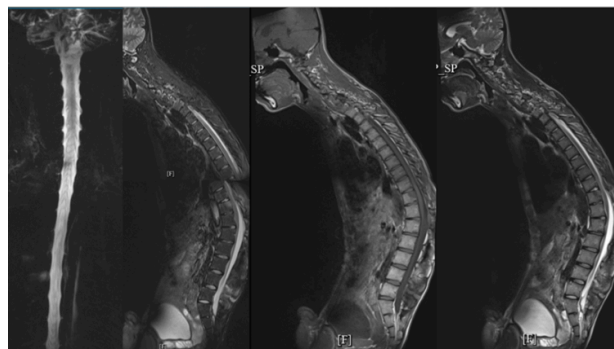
Results of MRI examination of Whole Spine (*Thoracic Center*) axial T1WI, T2WI; sagittal T1WI, T2WI, T1 FS + Myelography, without and with contrast.
